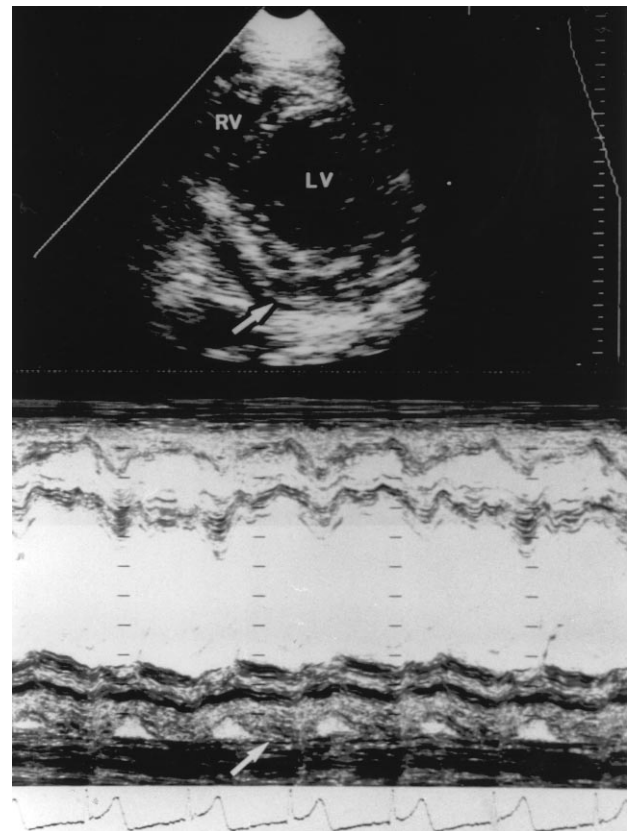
Echocardiographic evidence of a pericardial effusion in a 63-year old man (Patient 5) with an inferolateral infarction, with an echo-dense mass in the pericardial sac (arrow). In the M-mode image (bottom), the mass (arrow) appears to be attached to the epicardium of the inferior wall. LV = left ventricle; RV = right ventricle.
